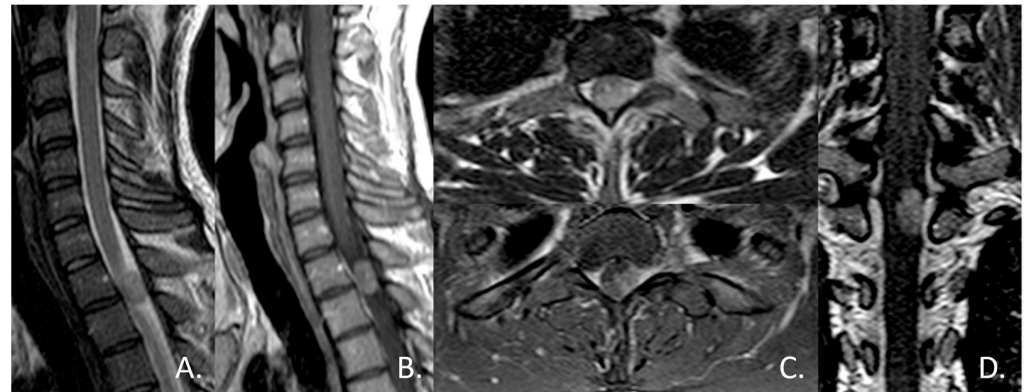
Sagittal T2-weighted (A) and contrast-enhanced T1-weighted (B) MR images showed a well-circumscribed, dorsally located, intradural extramedullary mass at the level of T1–T2, that caused anterior displacement of the spinal cord. Axial T2-weighted (C) and contrast-enhanced T1-weighted MR images confirmed the apparent location of the mass within the dural sheath, but outside the spinal cord, and coronal contrast-enhanced T1-weighted (D) better demonstrated the broad dural contact. The mass appeared as near iso-intensity to the spinal cord on T2, with homogeneous contrast enhancement.
